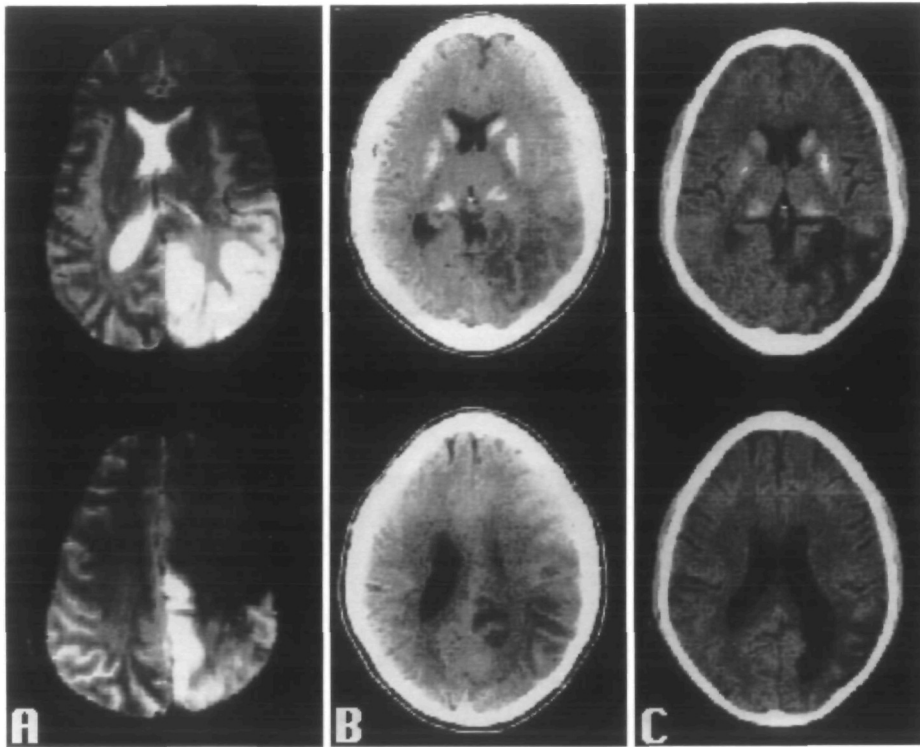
Magnetic resonance imaging performed 19 days (A) and computed tomography (CT) performed 13 days (B) after the strokelike episode show infarction involving the left parietal, posterior temporal, and occipital lobes in a multiterritorial distribution. CT performed 10 weeks after the strokelike episode (C) shows focal atrophy of the left parietal, temporal, and occipital lobes and enlargement of the left lateral ventricle. CT scans show extensive calcification of the basal ganglia.
